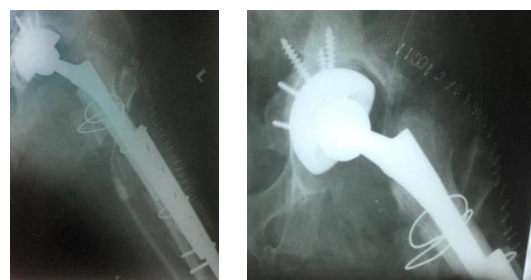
X-ray post-operative.
